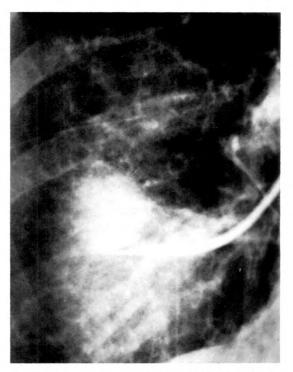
A chest roentgenogram revealed a mass in the right lower lobe of this 60 year old female. Bronchoscopy and sputum cytology revealed no abnormalities. The segment containing the lesion was catheterized and the tip of the catheter was placed as close as possible to the lesion. A small brush was then passed through the catheter and advanced to the mass; slides were prepared directly from the brush. Cells "exhibiting findings suspicious for malignancy" were present. At thoracotomy, a squamous cell carcinoma was removed.
